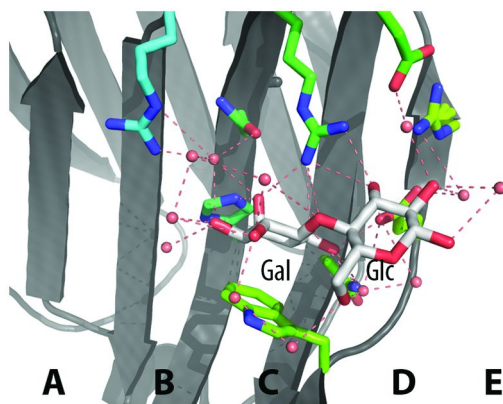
An ultra-high resolution (0.86Å) X-ray structure of galectin-3 in complex with lactose (10) showing the core β -D-galactoside situated in sub-site C and the D-glucose in sub-site D. Sub-sites A-B and E protrudes beyond gal-HO3 and glc-HO1, respectively, and are unoccupied. (see color insert)
